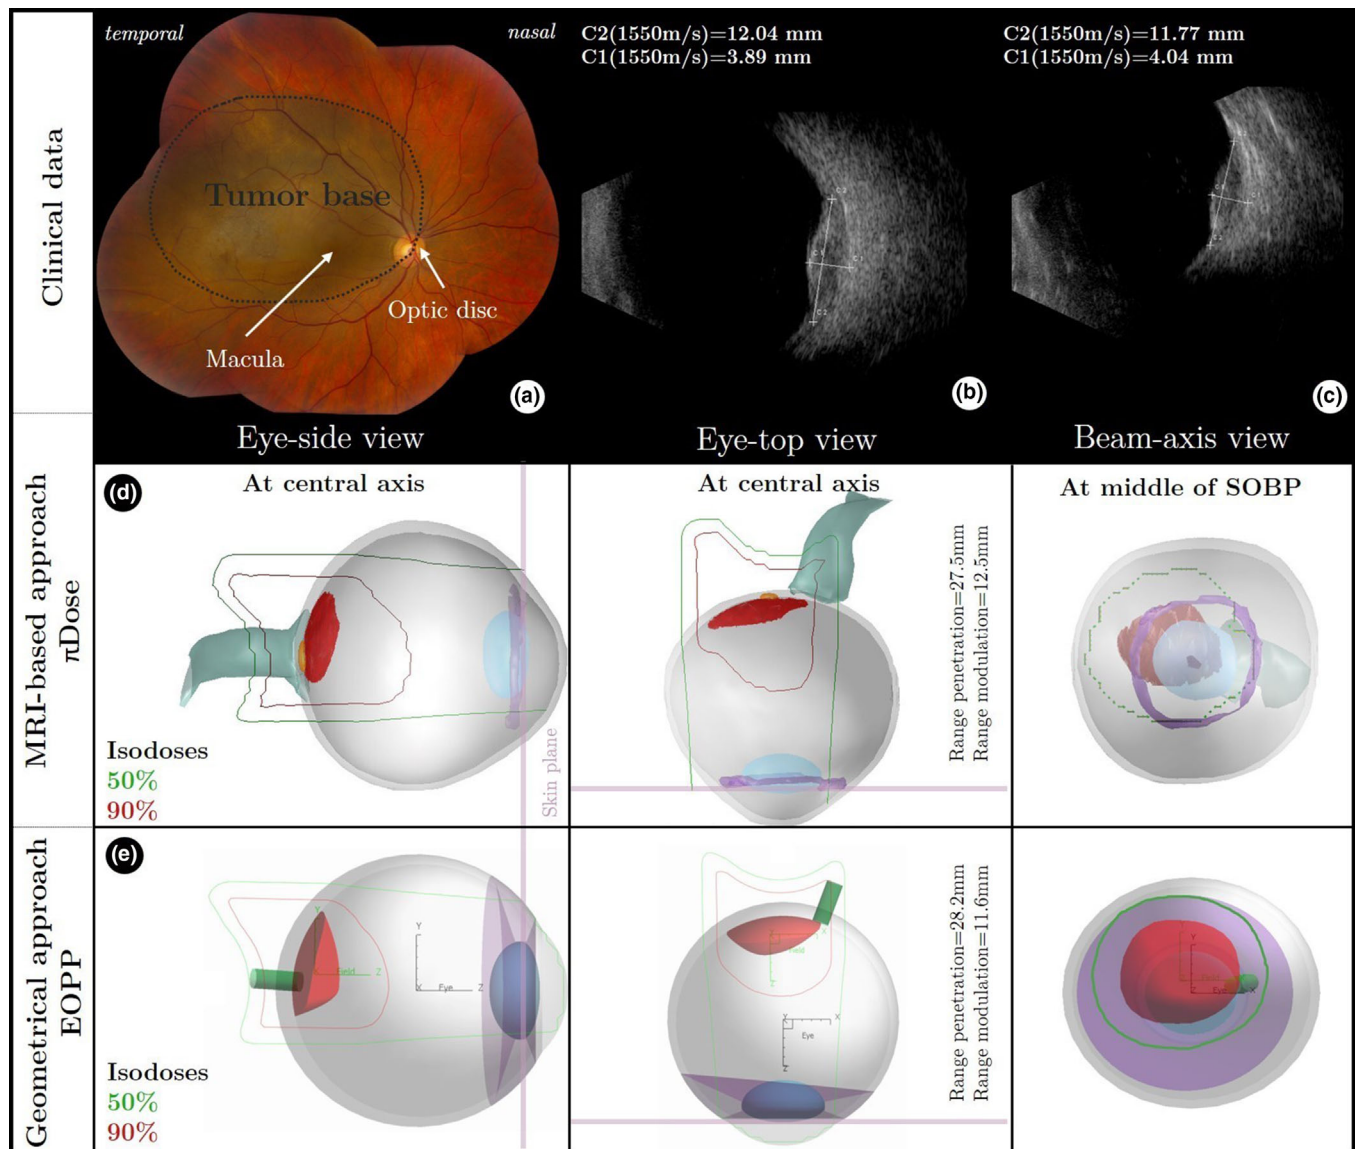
Treatment plan comparison for patient 3 (T1 posterior tumor). (a) Fundus photography and (b, c) Ultrasound images. (d) Three-dimensional magnetic resonance imaging (MRI)-based reconstructed eye and π Dose treatment plan. The macula (orange) is geometrically shaped. Fundus photography was used in conjunction with MR information for macula positioning and appreciation of the tumor base delineation. (e) Geometrical approach and EOPP TPS treatment plan. Eye and tumor were modeled based on the ultrasound images and fundus photography.
